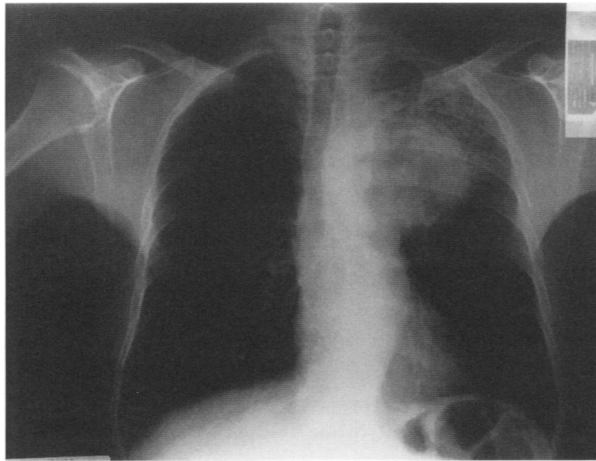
Chest radiograph showing a rounded mass arising from the left upper mediastinum, with an interstitial infiltrate in the left upper lobe.
